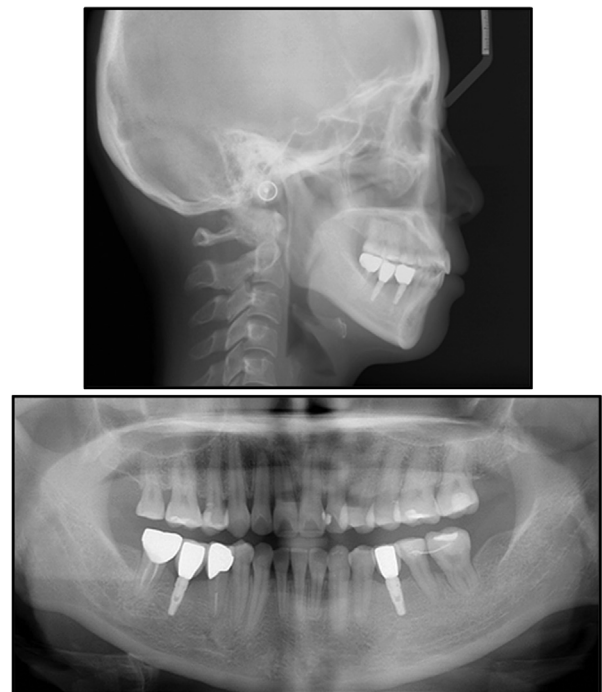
Posttreatment cephalometric (*above*) and panoramic (*below*) radiographs.
